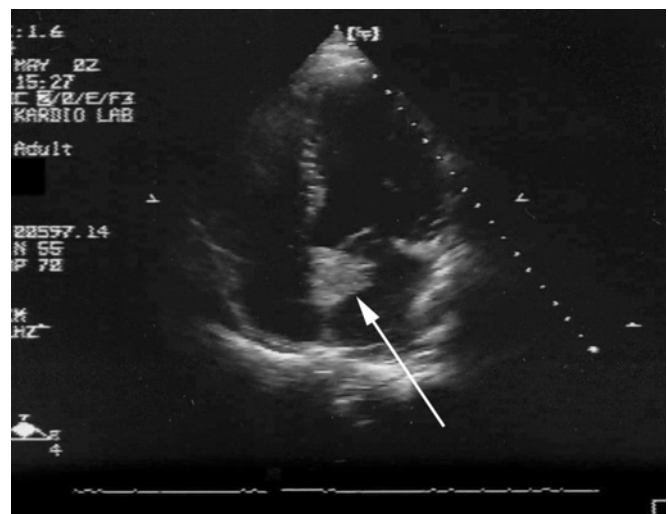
Transthoracic apical 4-chamber view echocardiogram showing a wide-based isoechogenic tumor located in the left atrium attached to the interatrial septum adjacent to the mitral valve annulus (arrow).
